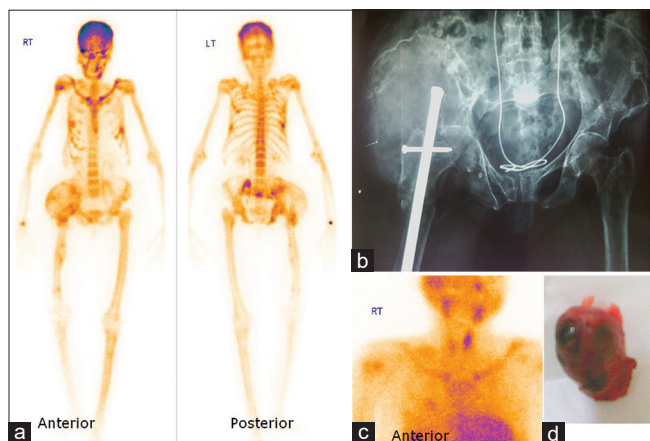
A 61-year female presenting with a lytic lesion involving the right acetabulum and right femoral head on the radiograph (b). Technetium-99m methylene diphosphonate bone scan (a) was performed as part of the metastatic survey. It showed findings of superscan with insufficiency fractures and brown tumor suggested the diagnosis of primary hyperparathyroidism which was confirmed on the parathyroid scintigraphy, done after injecting 555 MBq of technetium-99m methoxy-isobutyl-isonitrile (MIBI) scan and acquiring anterior images of neck and upper thorax at 20 min and 2 h which showed parathyroid adenoma in the left upper parathyroid gland (c). The patient was operated and parathyroid adenoma was removed (d). At present, the patient is doing well after 1 year of follow-up
